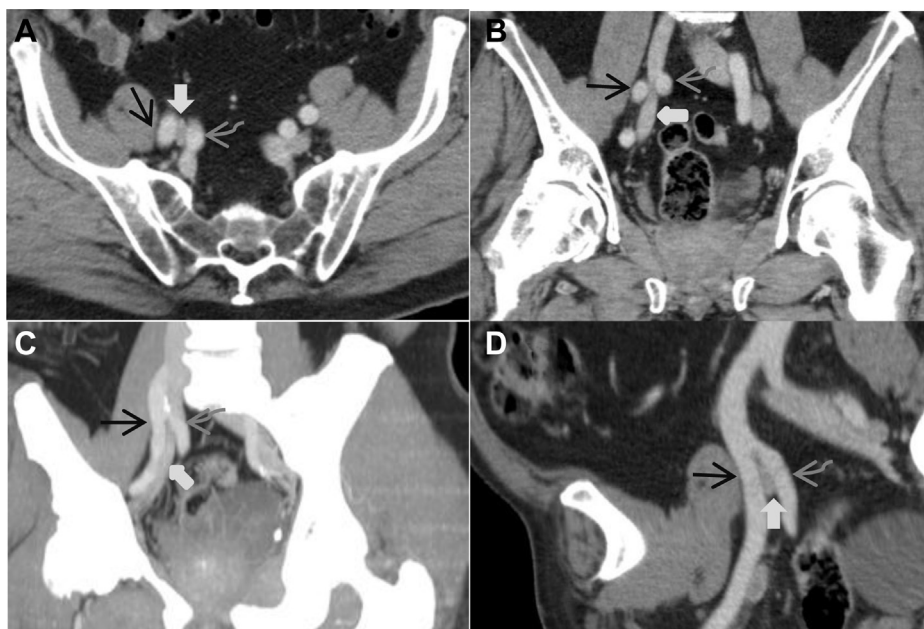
Contrast-enhanced computed tomography (CT) of the abdomen and pelvis. The *arrows* demarcate the position of the right external iliac artery (*black arrow*), right internal iliac artery (*gray curved arrow*), and right external iliac vein (*black block arrow*). A, Axial portal venous phase image of the pelvis demonstrating compression of the right external iliac vein between the right internal and external iliac arteries. B, Coronal portal venous phase image demonstrating compression of the right external iliac vein between the right internal and external iliac arteries. C, Coronal maximum intensity projection image demonstrating compression of the right external iliac vein between the bifurcation of the right internal and external iliac arteries. D, Reconstructed image demonstrating compression of the right external iliac vein between the bifurcation of the right internal and external iliac arteries.
